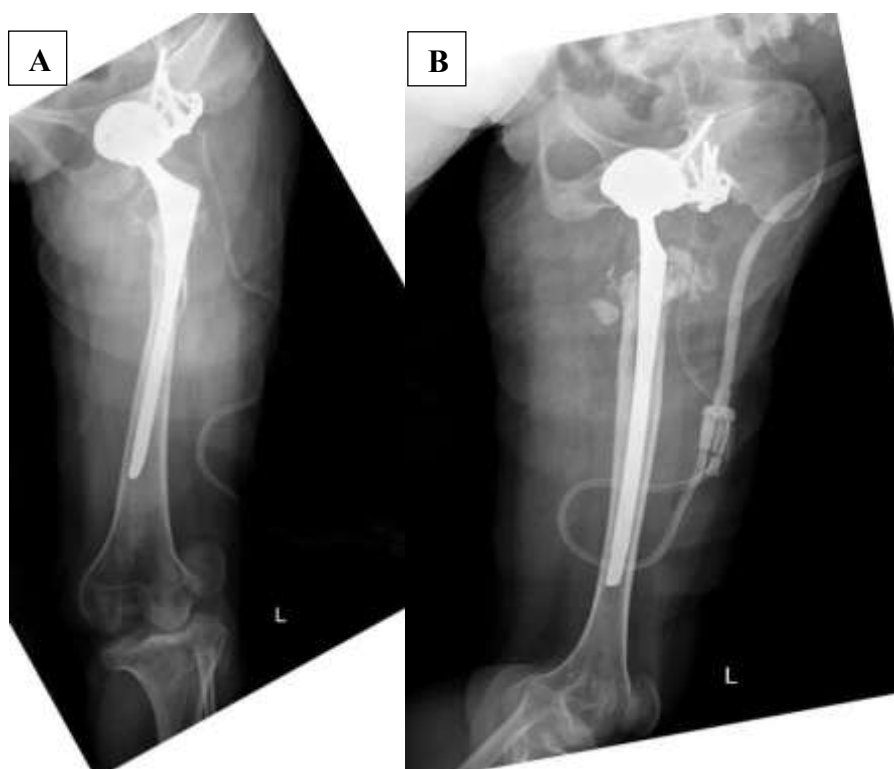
Postoperative anteroposterior (A) and lateral (B) radiographs of the left femur demonstrating cementless total hip arthroplasty following hip reconstruction for suspected neglected tuberculous coxitis.
